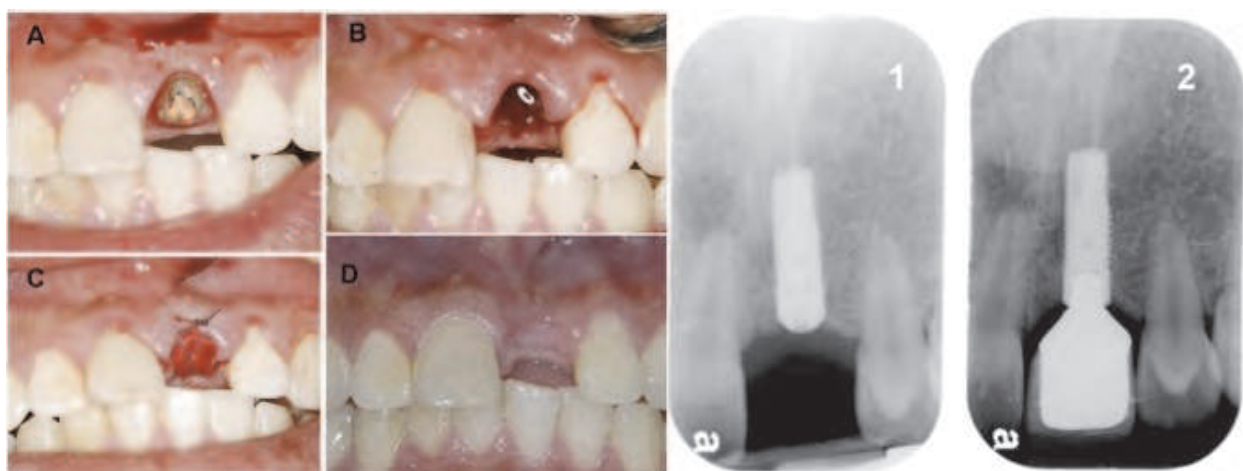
Clinical photos of tooth #9 A) prior to extraction, B) immediately following extraction, C) following DFDBA and collagen membrane placement, D) 4 months following extraction. Radiographs of implant at the same site 1) at implant installation and 2) one year following implant installation.
